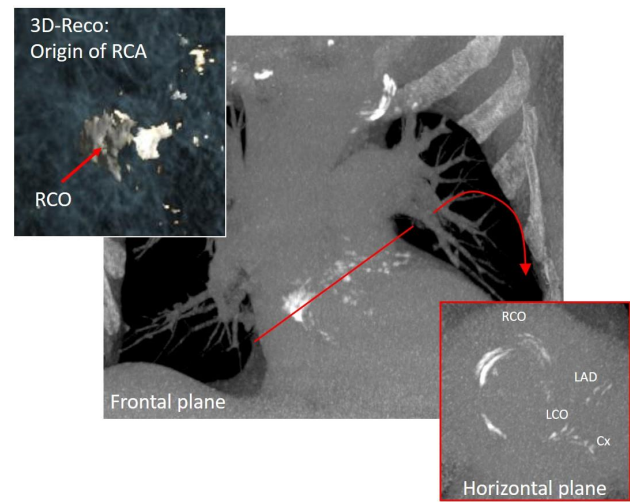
Preoperative 3d-CT reconstruction showing the severely calcified aortic root and coronary arteries.
